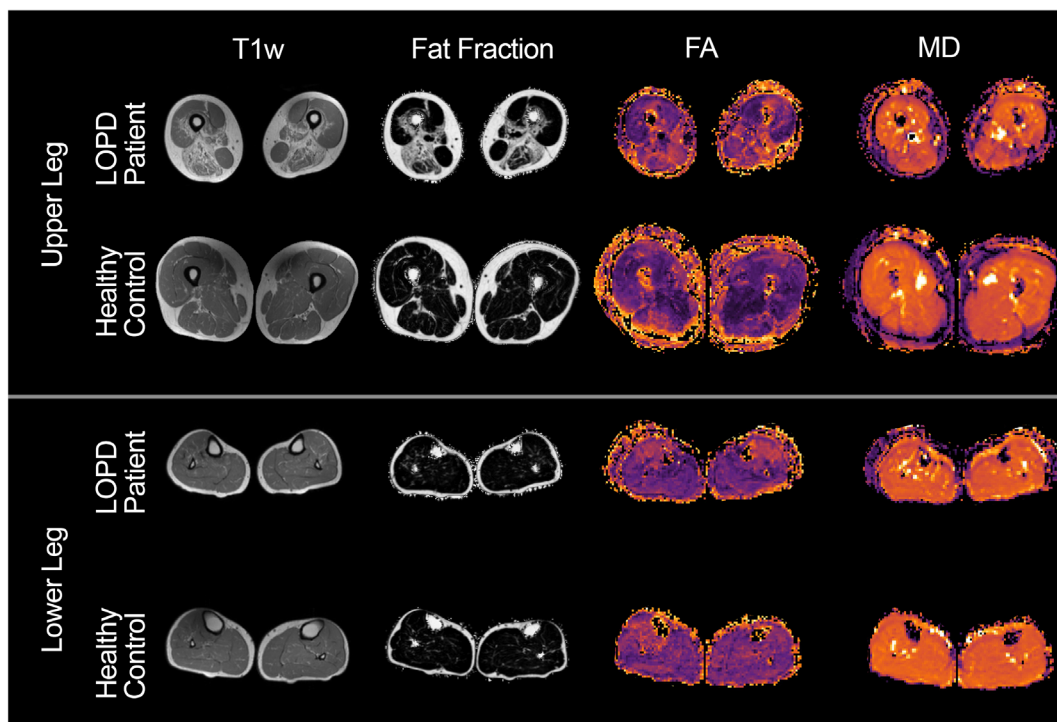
Example images of the applied MRI sequences. Upper leg: axial slices of MR images; proximal thigh muscles of late onset pompe disease (LOPD) patient and healthy control (HC). MRI sequences from left to right: T1w, mDixon fat-fraction, fractional anisotropy (FA), mean diffusivity (MD). T1w, mDixon, FA, and MD map show fatty infiltration and signal alteration in posterior thigh muscle compartment. Lower leg: axial slices of MR images; proximal calf muscles of LOPD patient and HC. No visible alterations [Color figure can be viewed at wileyonlinelibrary.com]
